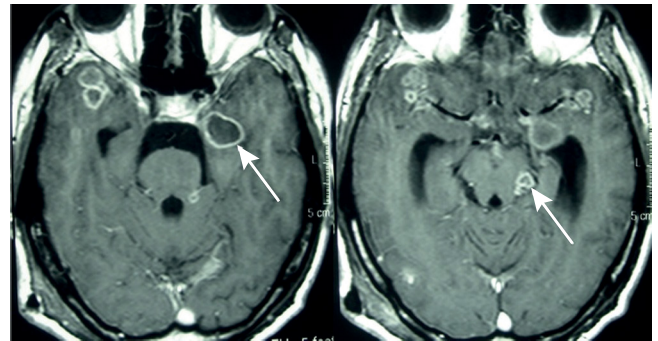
Axial-T1 weighted brain MRI shows multiple lesions at the base of the skull with gadolinium enhancement in a patient with tuberculosis of the nervous system.
